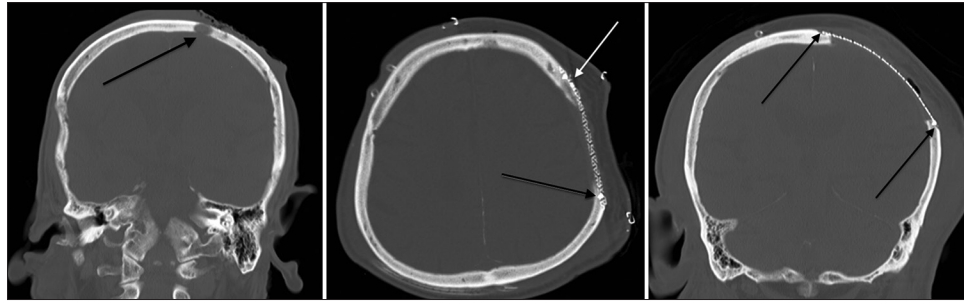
Preoperative CT shows that the tumor causes bone irregularities and extends into the parenchyma by destroying the bone (black arrow)-LEFT Postoperative CT shows that the mesh edges are seated in the groove and same level with the bone (black-white arrow)-MIDDLE It reduces the pressure exerted by the implant on the skin by not creating an extra height. In addition, the contact of the sharp tips with the skin is minimized (middle)-RIGHT CT: Computed tomography
